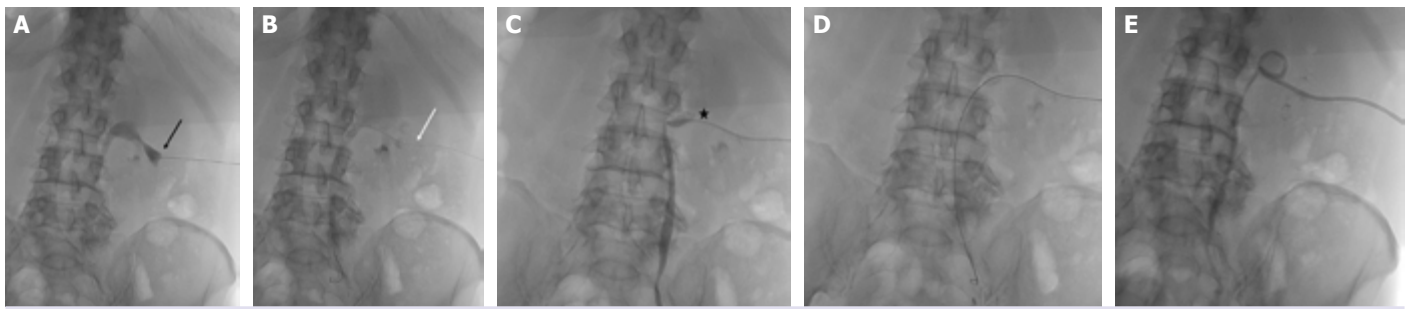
(A) Radiograph following the US-guided puncture of the renal pyramid using a Chiba needle. A small volume of diluted contrast medium was carefully injected through the needle (indicated with a black arrow) to visualize the renal collecting system. (B) A 0.018-inch guidewire (indicated with a white arrow) was introduced through the Chiba needle into the renal collecting system. (C) The 0.018-inch guidewire was exchanged with a GaltStick introducer system (indicated with an asterisk) to provide a more stable access point. (D) A 0.035-inch Amplatz guidewire was carefully advanced into the ureter, ensuring accurate positioning. (E) An 8 F drainage catheter was successfully inserted.
